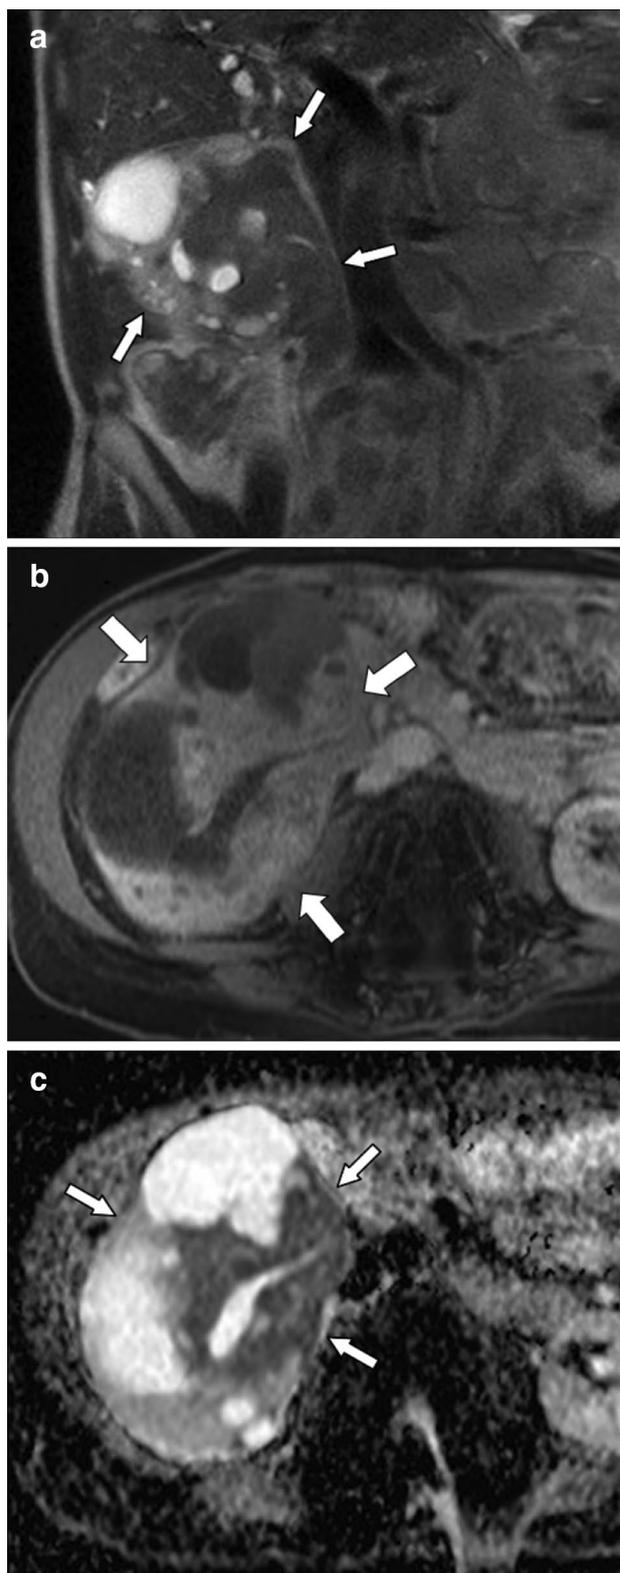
Other iatrogenic immunodeficiency lymphoproliferative disorder in the right kidney of a 57-year-old woman related to infliximab treatment of rheumatoid arthritis. The right kidney is diffusely enlarged. a Coronal HASTE and b axial T1 FS contrast-enhanced MRI demonstrate an infiltrative, T2 hypointense, enhancing soft tissue lesion in the right renal collecting system (arrows). c Hypointense signal on ADC map demonstrates restricted diffusion within this lesion (arrows)
